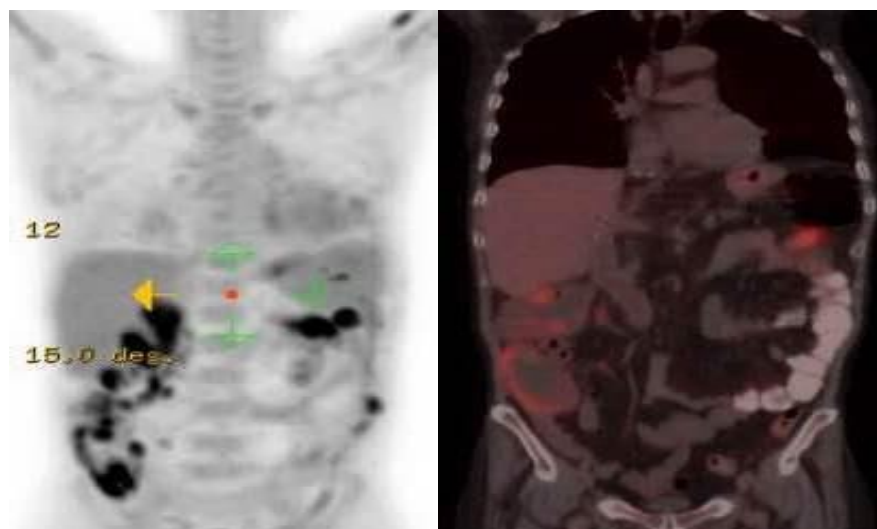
PET-CT images showing high FDG uptake signals in large bowel loops, corresponding to colonoscopy lesions in ascending and transverse colon.
